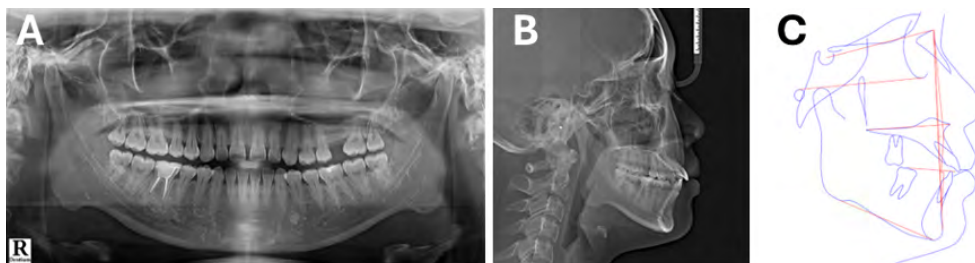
Pre-treatment panoramic (A), lateral cephalometric (B) radiographs, and tracing (C).
